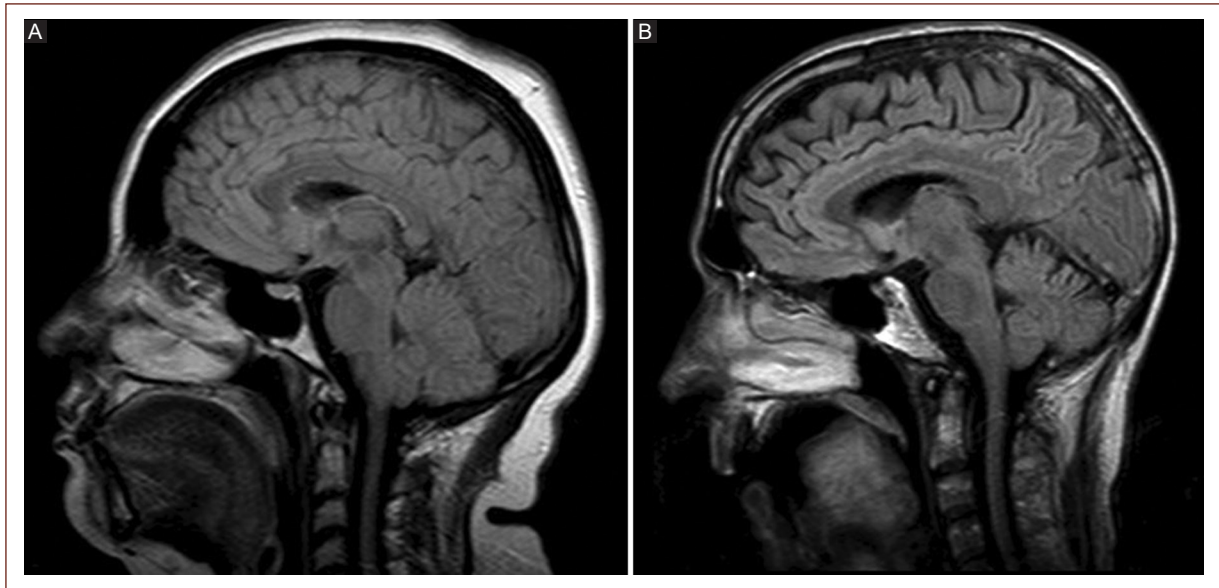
Bright tongue sign. Magnetic resonance imaging (MRI) sagittal T1-weighted FLAIR sequence A: in a 41-year-old female with 6 months from onset to diagnosis of bulbospinal amyotrophic lateral sclerosis (ALS). Shape and signal intensity of her tongue were normal, B: MRI in a 49-year-old man with 23 months from onset to diagnosis of bulbospinal ALS. Abnormalities in shape, position, and hyperintense signal of the tongue were detected.
